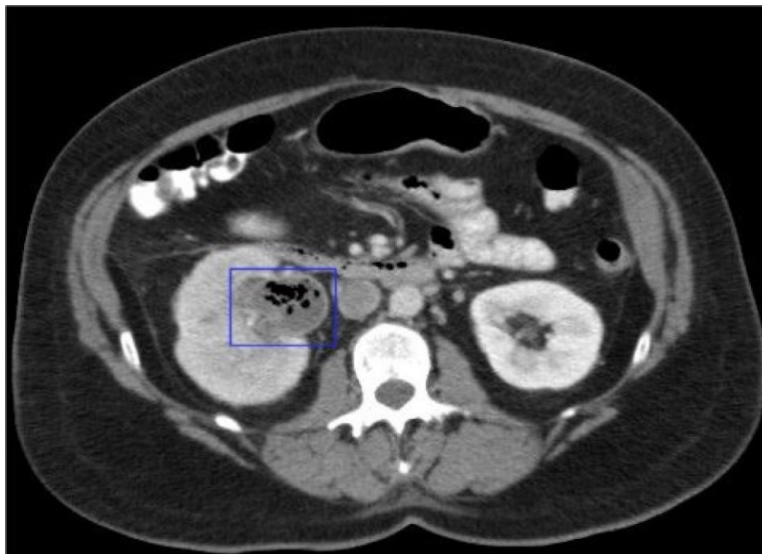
CT KUB Class 1 EPN
